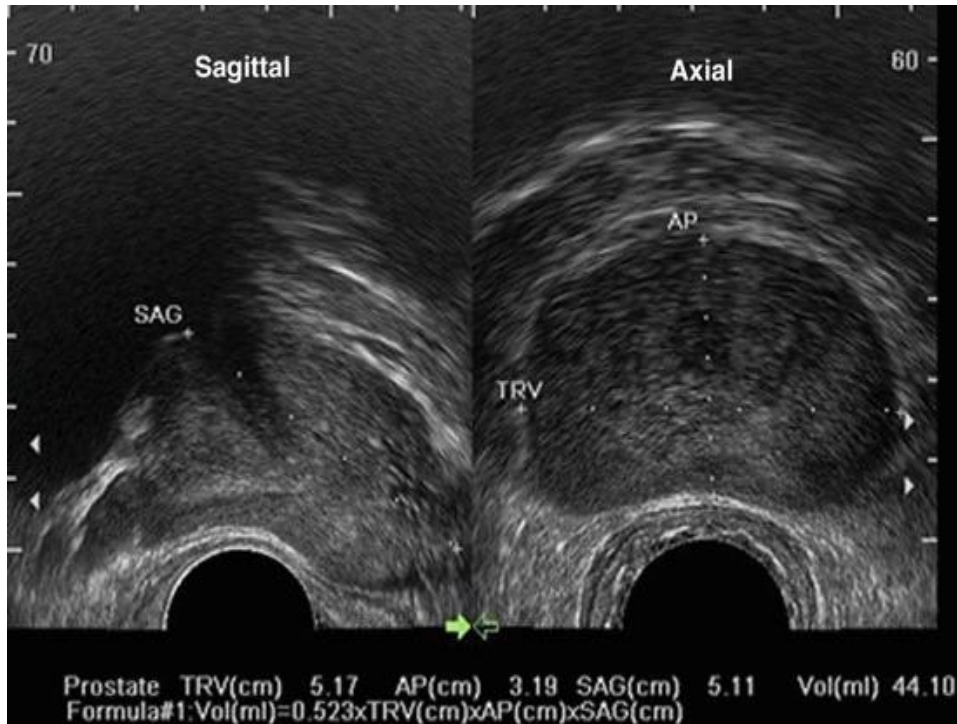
Prostate volume is measured in three dimensions using transrectal sonograms. The width (TRV) and height (AP) are measured in transverse view. The length (SAG) is measured in sagittal view. The machine automatically calculates the volume or uses the ellipsoid formula ($0.52 \times \text{transverse diameter} \times \text{A-P diameter} \times \text{longitudinal diameter}$) to estimate the volume (1,2), which is similar to the methodology used in the current study.
